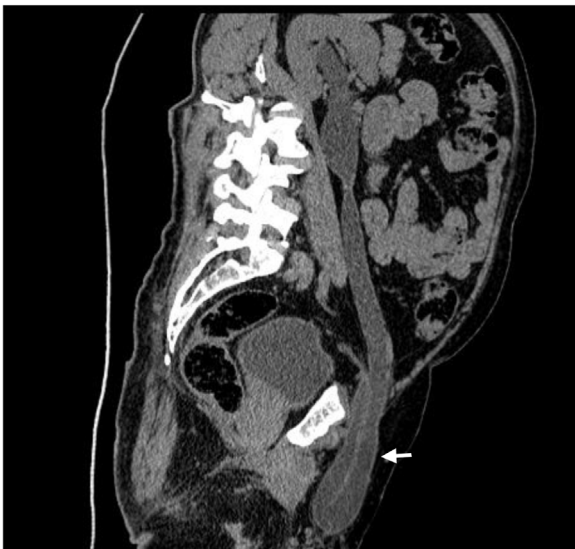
A plain CT of KUB showing the left ureter coursing into the left inguinal canal, descending into the scrotum, and looping back to enter the bladder (arrow).
